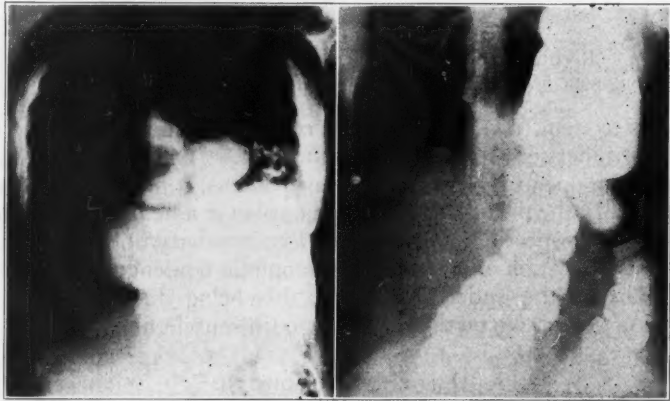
Roentgenograms showing hernia of the diaphragm on the left. completely healed in a few days, while others may extend to the muscular coat or may even penetrate the wall of the colon and involve the peritoneum.
